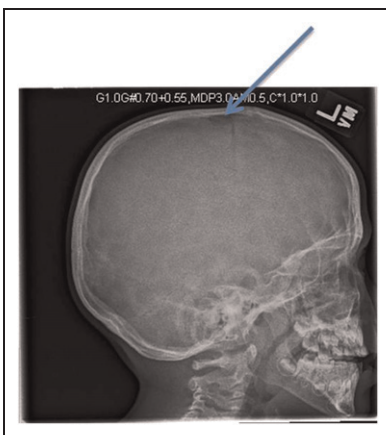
Lateral radiograph demonstrating that the skull tapers smoothly at the margin of the lucent defect.
